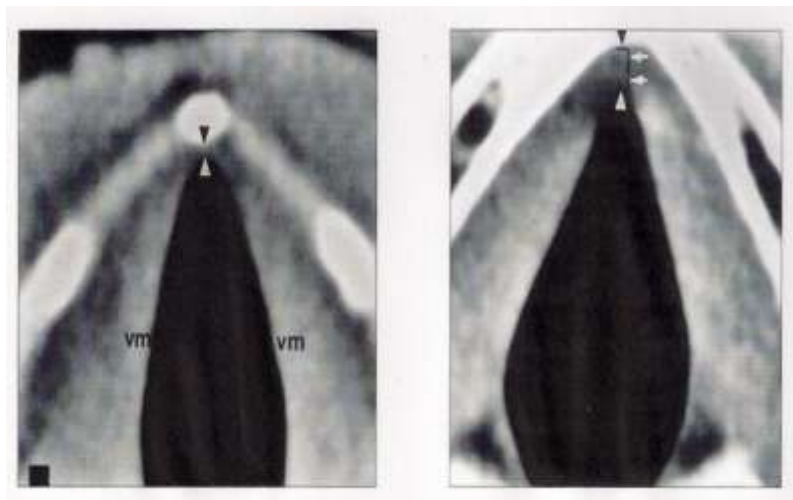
Anatomic variations in size of the AC (Left) Axial CT neck with normal AC in 55 year old woman. Width of AC shown by Arrowheads; 1.0mm (Right) Axial CT neck with normal AC in 45 year old man. Width of AC by Arrowheads 2.2mm (*Kallmes et al., 1997*).
